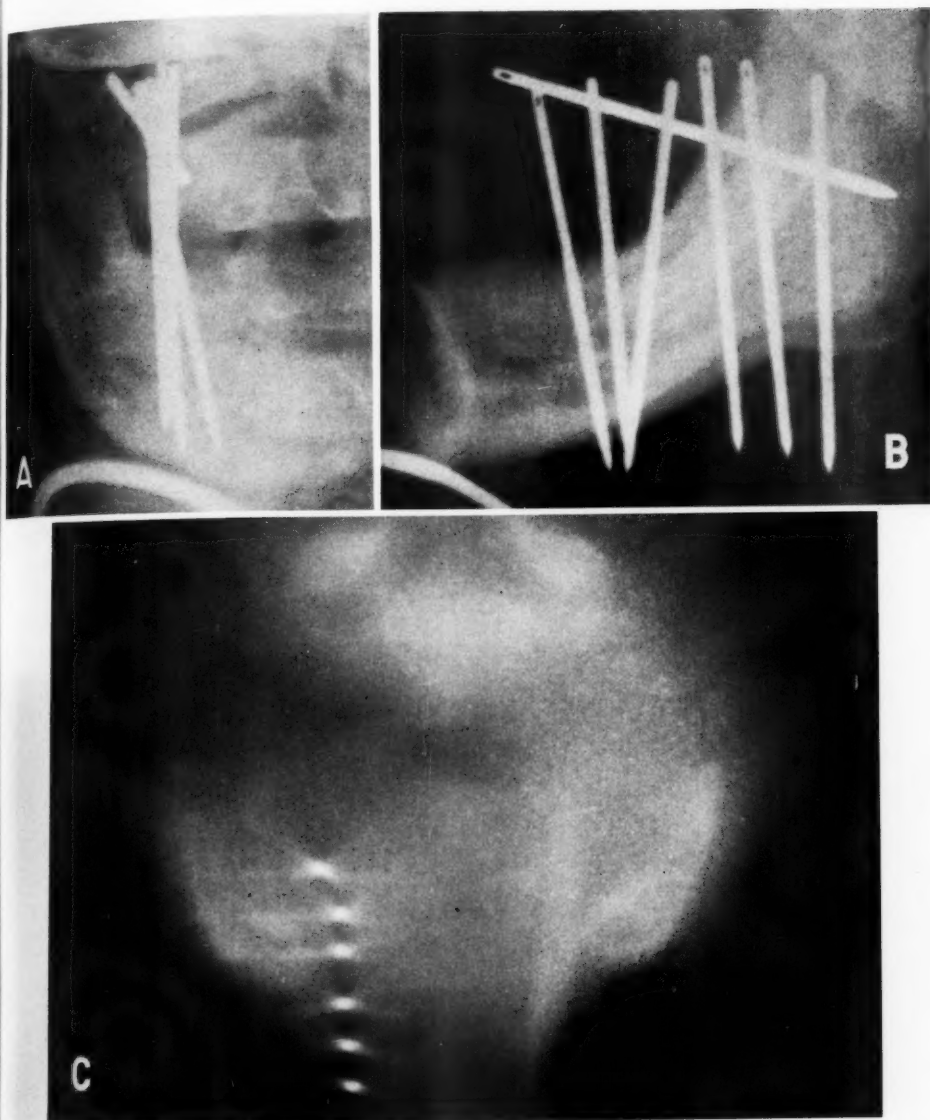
Single plane implant in floor of the mouth. A. and B. Routine radiographs. C. Transverse tomogram.
